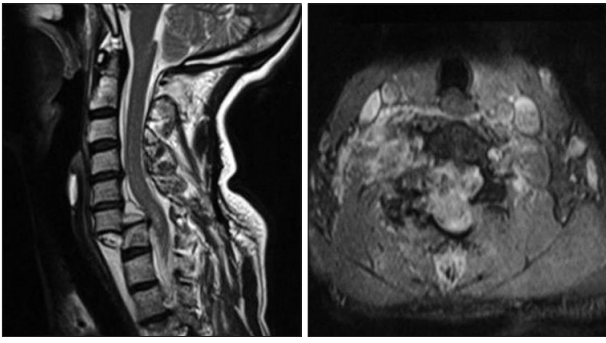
Magnetic resonance imaging of the cervical spine reveals total spondyloptosis at the C6-C7 level. Note the large disc which causes compression and edema in the lower spinal cord.
